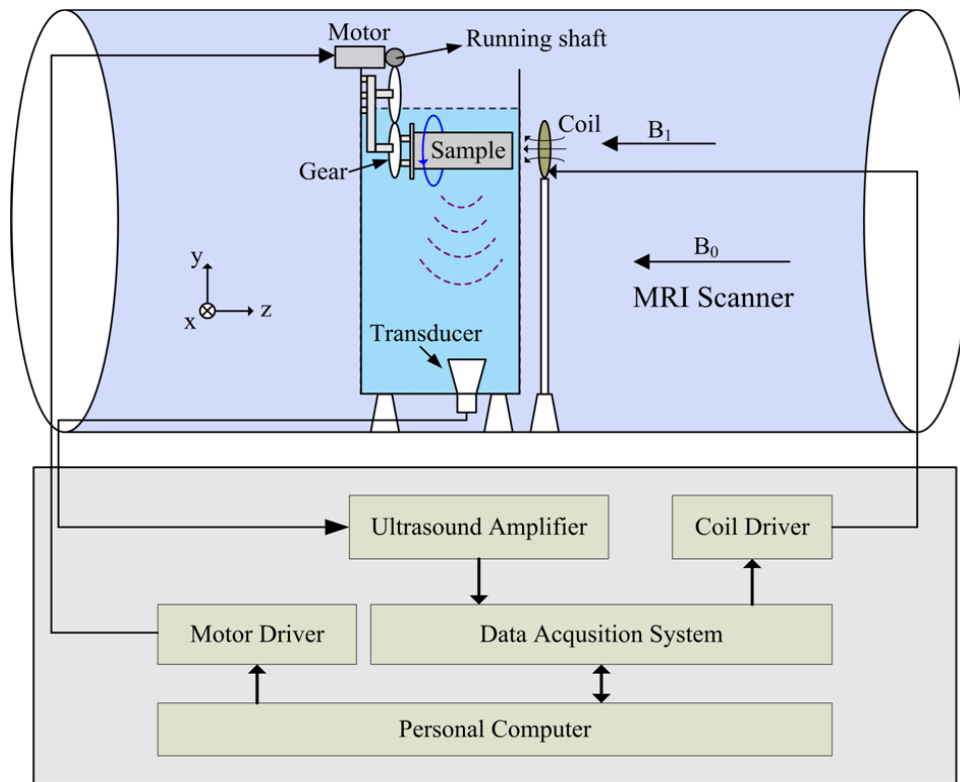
Hardware setup of MAT-MI imaging system under MRI scanner for biological tissue imaging.
